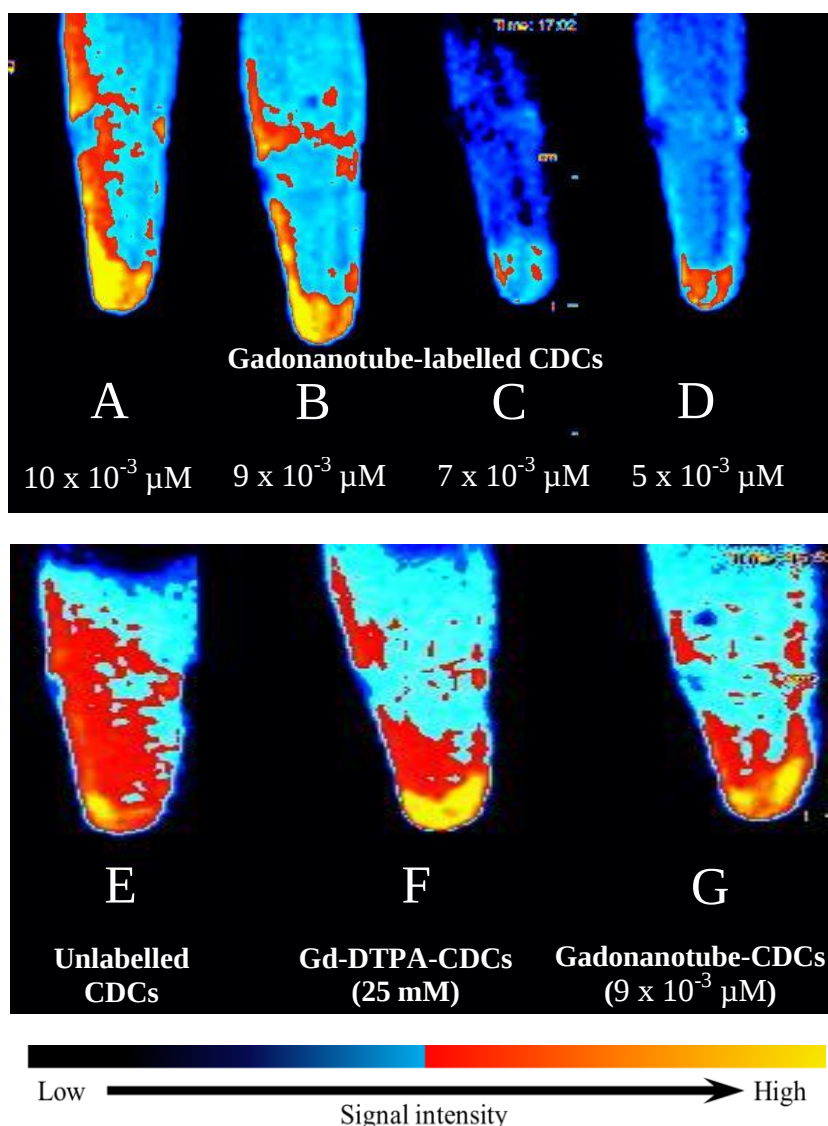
T1-weighted MRI of gadonanotube-labelled CDCs at $10 \times 10^{-3} \mu\text{M}$ (A), $9 \times 10^{-3} \mu\text{M}$ (B), $7 \times 10^{-3} \mu\text{M}$ (C), $5 \times 10^{-3} \mu\text{M}$ (D), and unlabelled control (E). Signal intensity from gadonanotube-labelled CDCs ($9 \times 10^{-3} \mu\text{M}$, G) was lower than that of Gd-DTPA-CDCs (25 mM) (F). (n=1).
